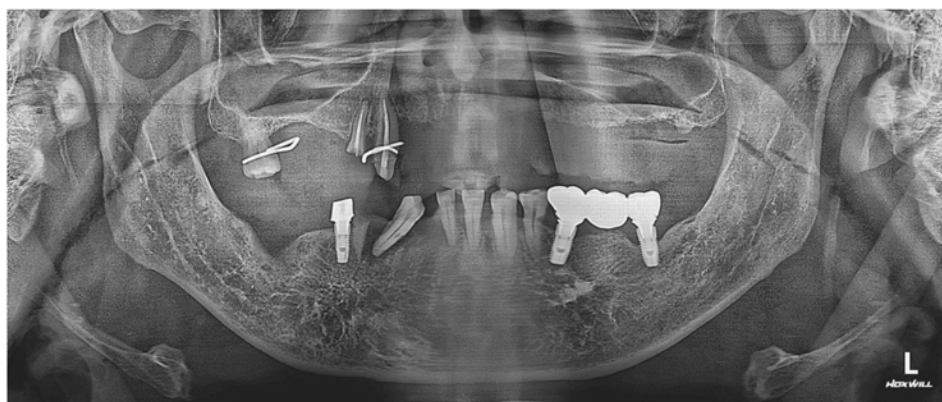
Panoramic radiograph on the first visit.
